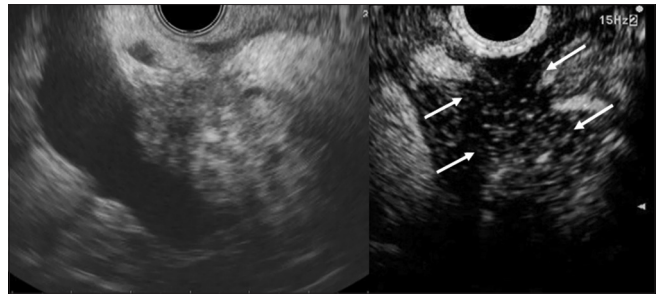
A case of unclear isoechoic pancreatic cancer in the pancreatic head. Conventional endoscopic ultrasound (left image) does not show the edge of the tumor clearly. Contrast-enhanced harmonic endoscopic ultrasound (right image) shows the tumor (arrows) as hypo-enhancement with clear margin to the surrounding tissue
